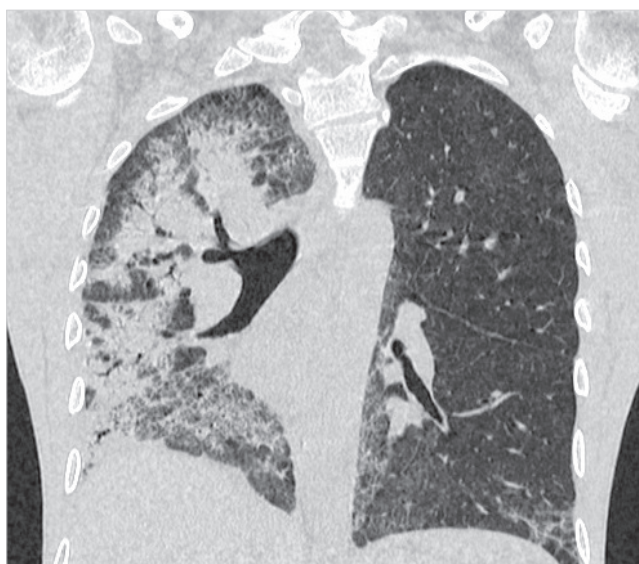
CT scan. Right-sided viral pneumonia associated with CMV.
